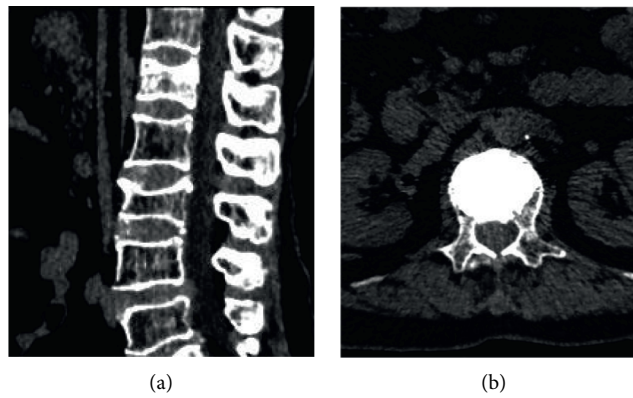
73-year-old female with a compression fracture of the first lumbar vertebra. (a) Preoperative CT. (b) Postoperative CT of lumbar 1 vertebral body.
